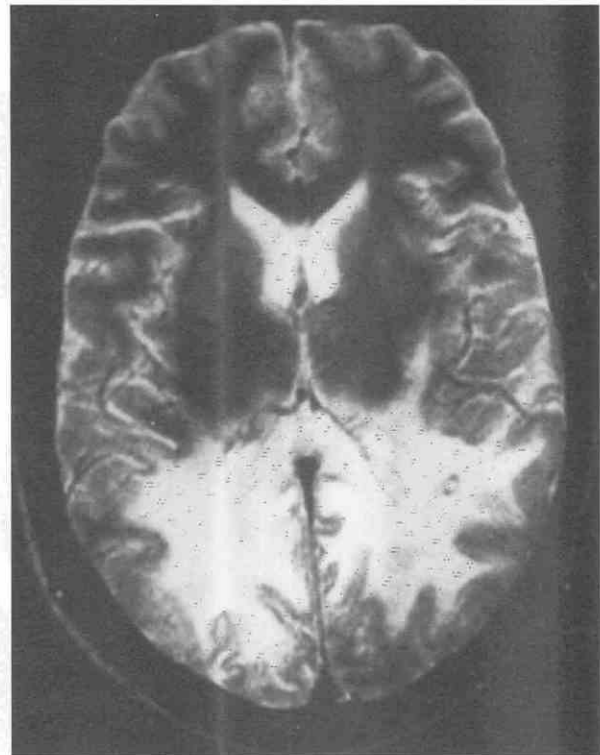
Progressive multifocal leukoencephalopathy. T2-weighted image shows high signal intensity in the parieto-occipital white matter bilaterally.
